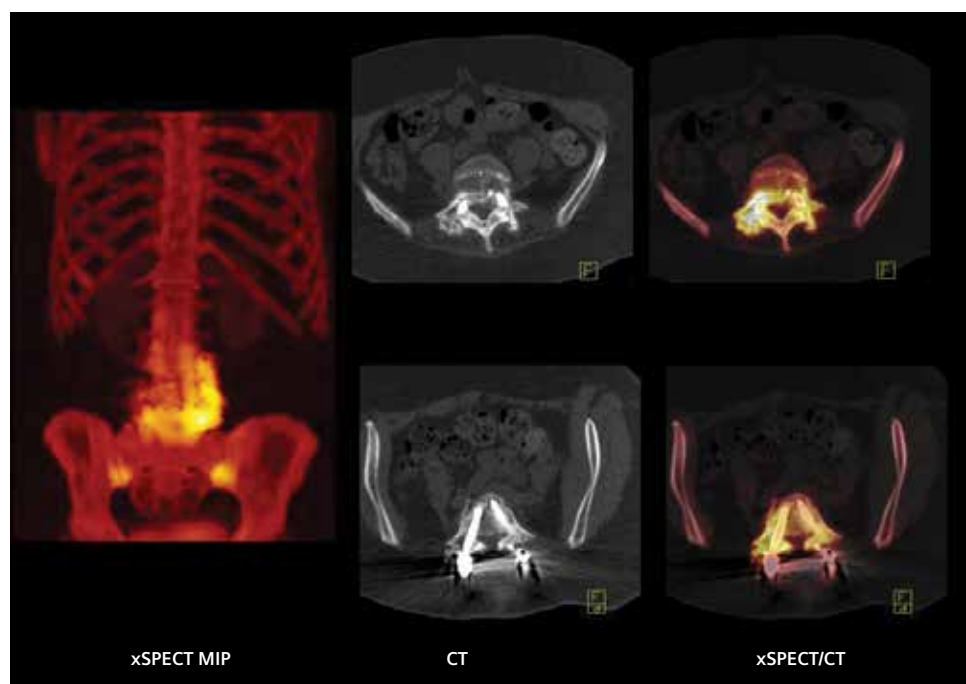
Posterior view of xSPECT Bone MIP shows increased uptake in the right-sided L5 screw along with reactive uptake in the right L4 and L3 screws. CT and fusion of CT and xSPECT Bone at different levels within the L5 vertebral body delineate the entire length of the right L5 screw and show periprosthetic linear increased uptake that is typical of loosening.
